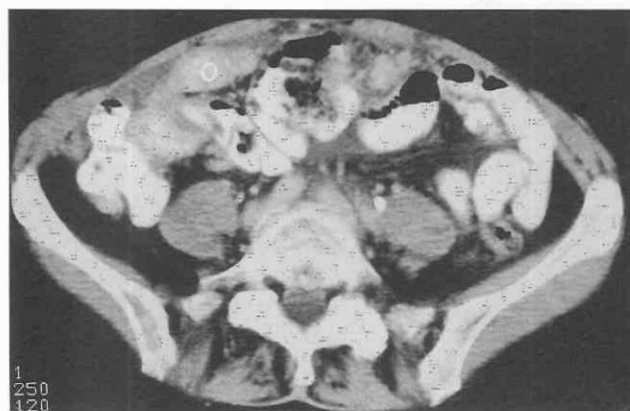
Calcified omental cake. CT scan through the upper pelvis shows omental metastasis (O) that mimics partially opacified small bowel.
